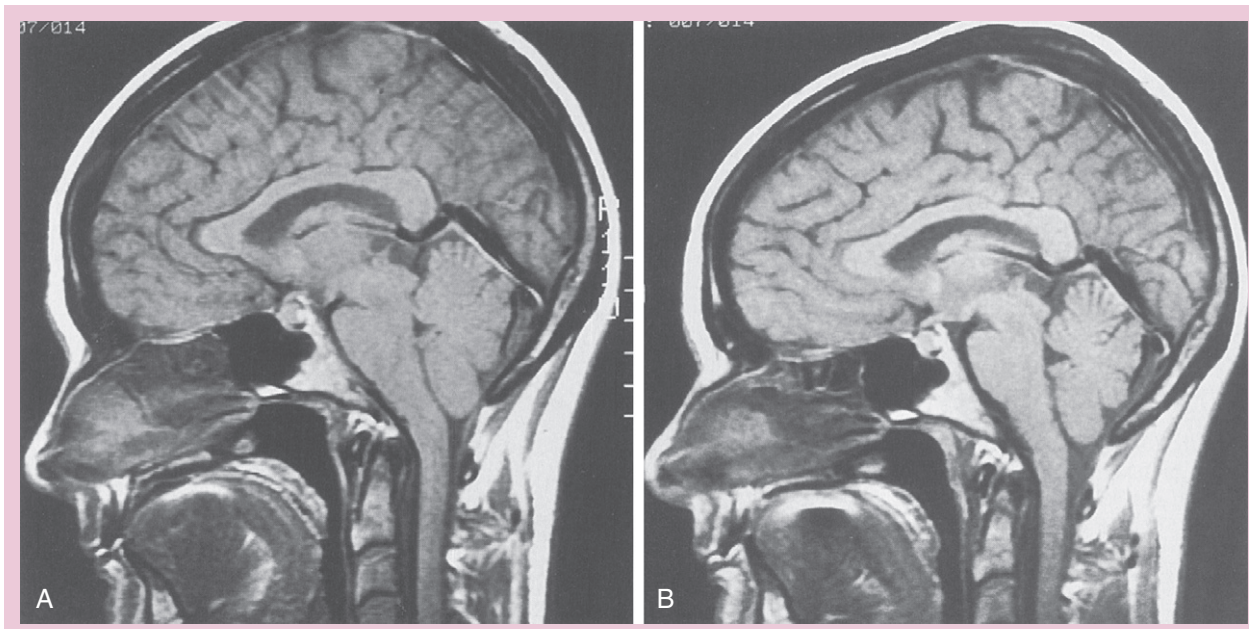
Anatomy of a “low-pressure” headache. A, A T1-weighted sagittal magnetic resonance image demonstrates a “ptotic brain” manifested as tonsillar herniation below the foramen magnum, forward displacement of the pons, absence of the suprasellar cistern, kinking of the chiasm, and fullness of the pituitary gland. B, A comparable image of the same patient after an epidural blood patch and resolution of the symptoms demonstrates normal anatomy. (From Drasner K, Swisher JL. In Brown DL [ed]. *Regional Anesthesia and Analgesia*. Philadelphia, WB Saunders, 1996.)
